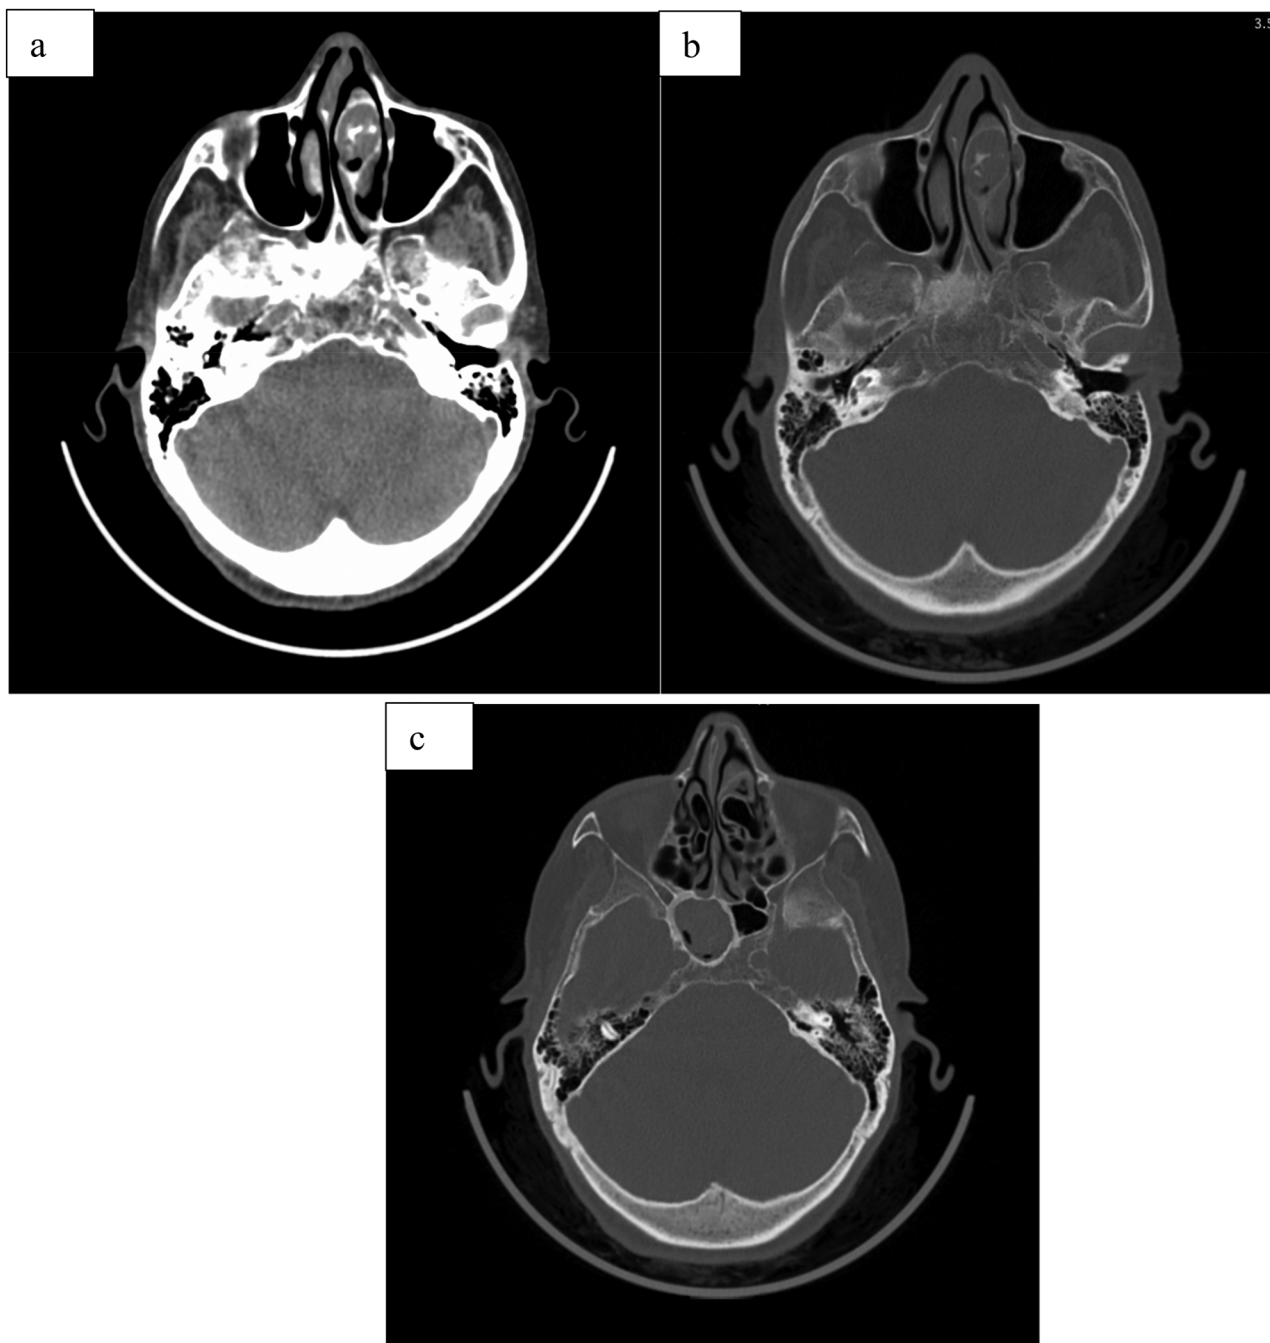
Paranasal computed tomography (CT) scan: (a), (b) axial section: concha bullosa of the left middle turbinate filled with a high-density material, and (c) axial section: chronic sinusitis of the right sphenoidal compartment.
